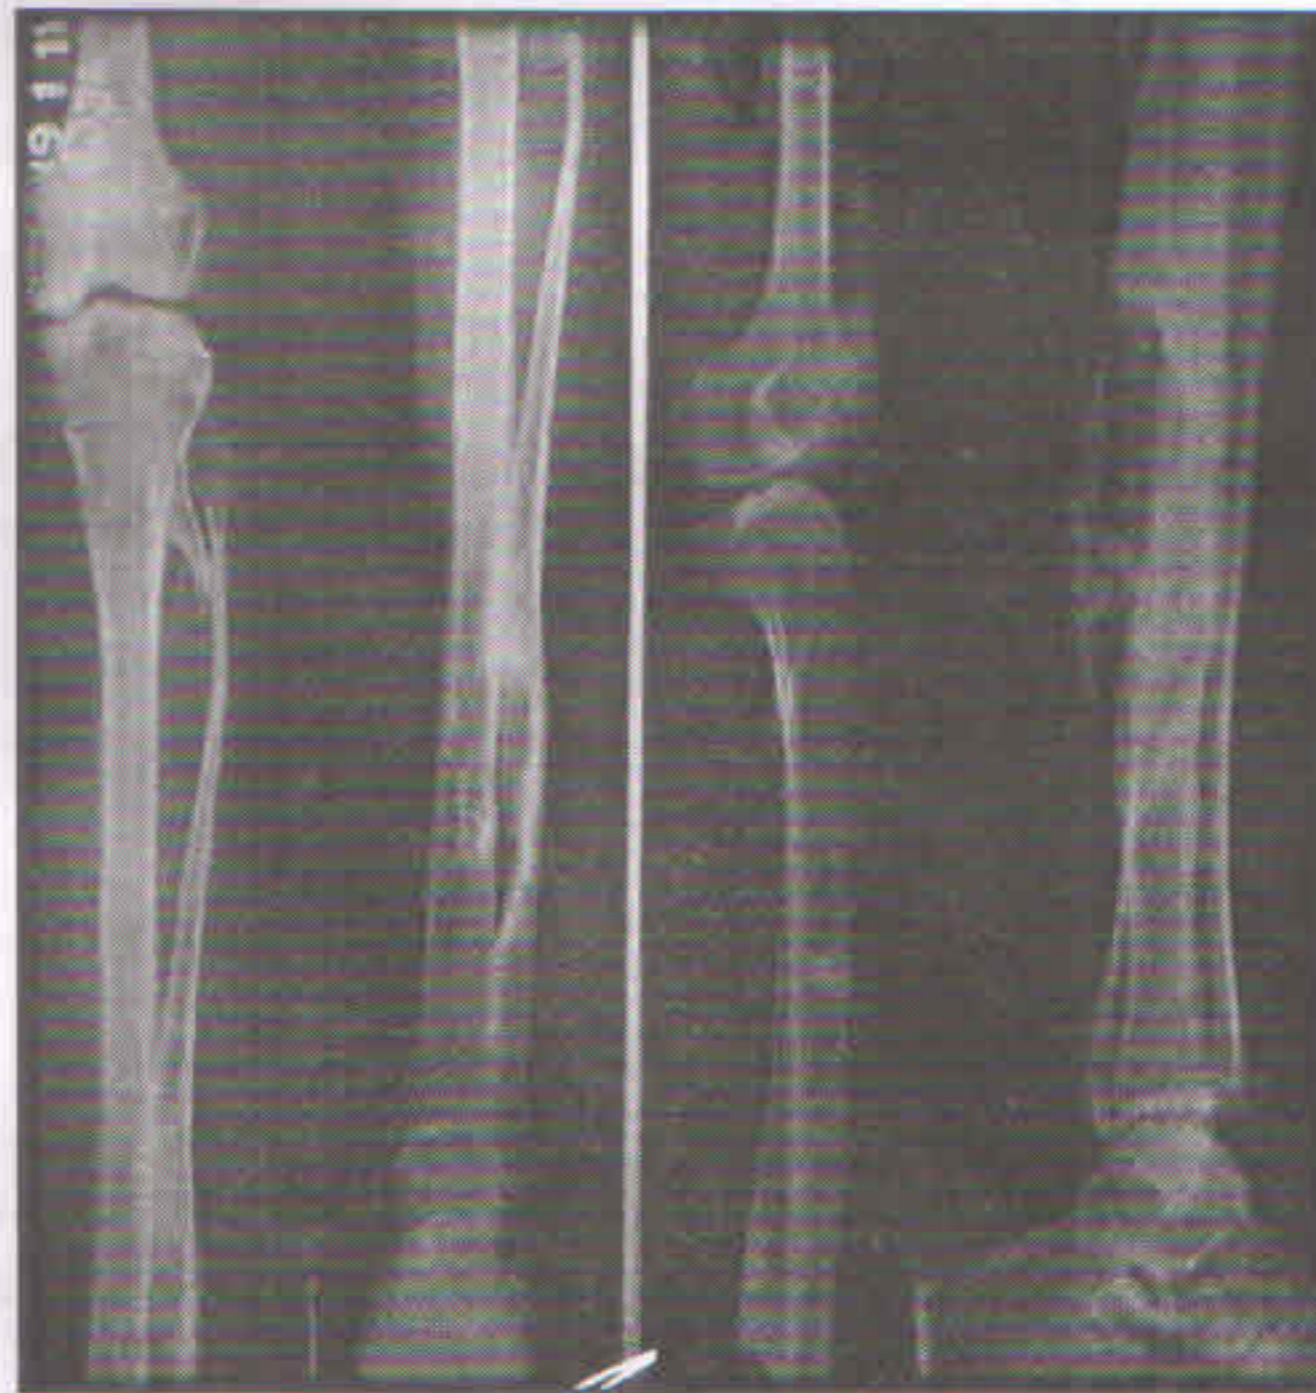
Antero-posterior and lateral radiograph of left leg showing a bony outgrowth arising from upper end of tibia with deformed fibula. Areas of cortical irregularity and thickening with marrow sclerosis are seen in lower shaft of left fibula.
